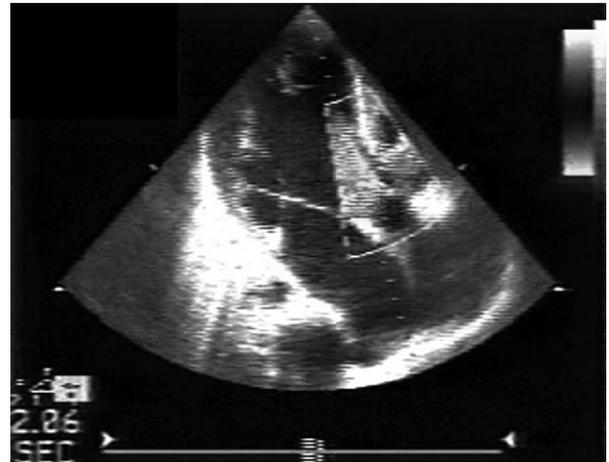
Apical five chamber view shows the small defect in sub-aortic position with left-to-right shunt.
